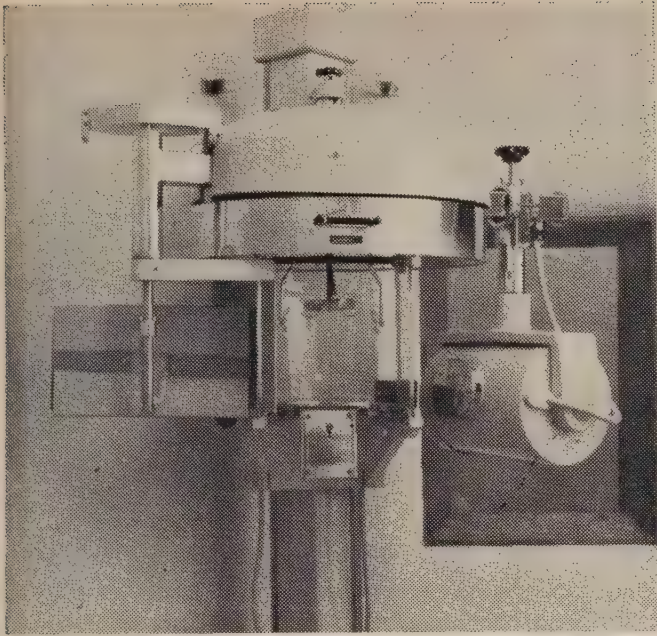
Orthopantomograph.
